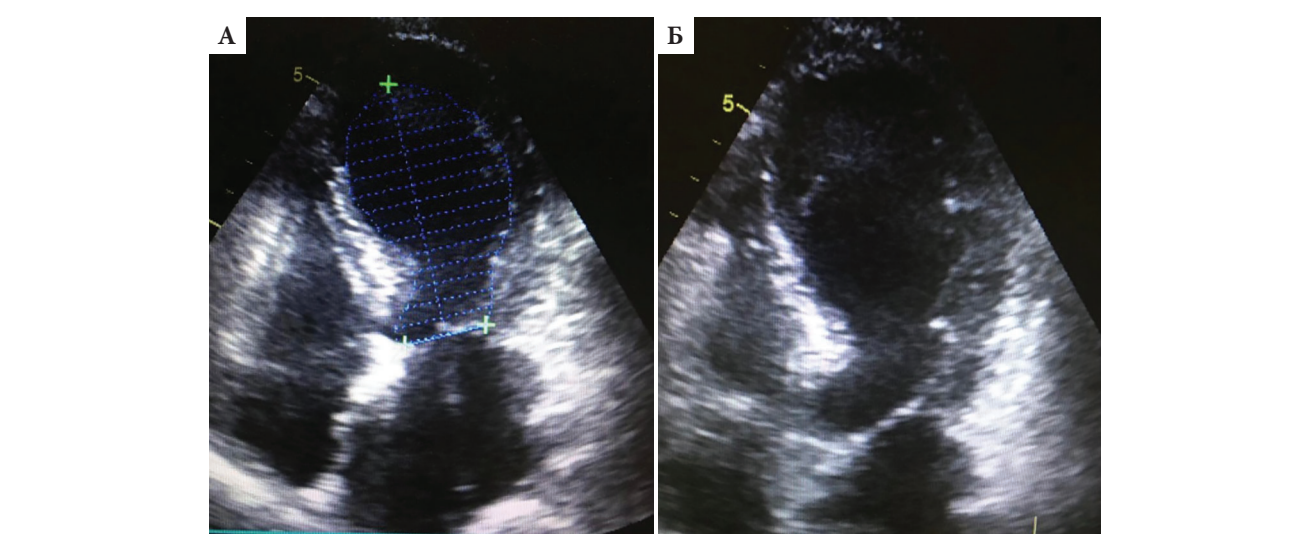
Echocardiography of a patient in the postoperative period, after the onset of pain in the chest, apex ballooning, B-mode, systole: A — apical 4-chamber position, B — apical 5-chamber position
